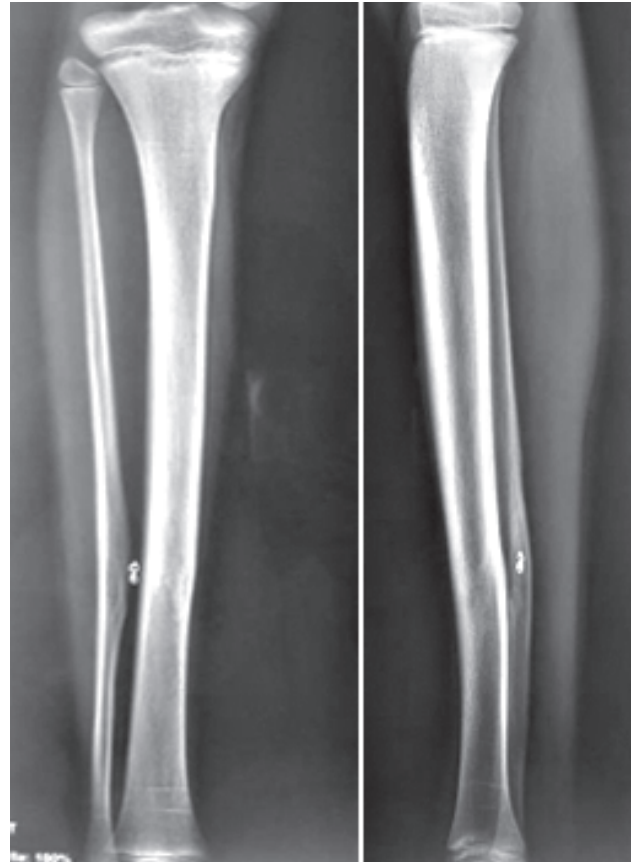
Right leg X-ray 6 months post-operative showing disappearance of the lacuna after 6 months
